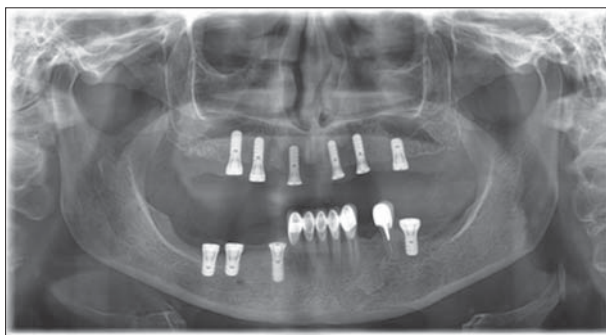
Postoperative panoramic X-ray
